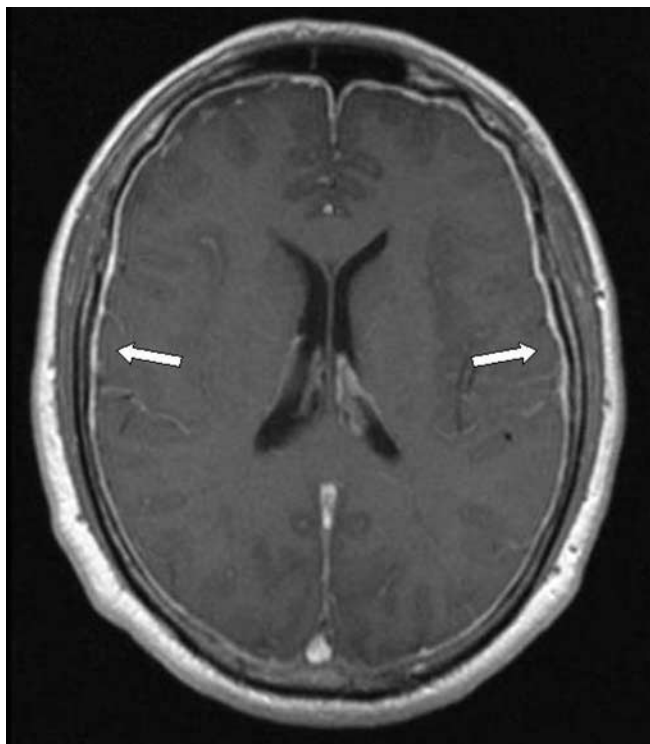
Contrast-enhanced axial MR images of the brain showing diffuse pachymeningeal enhancement (arrows)
